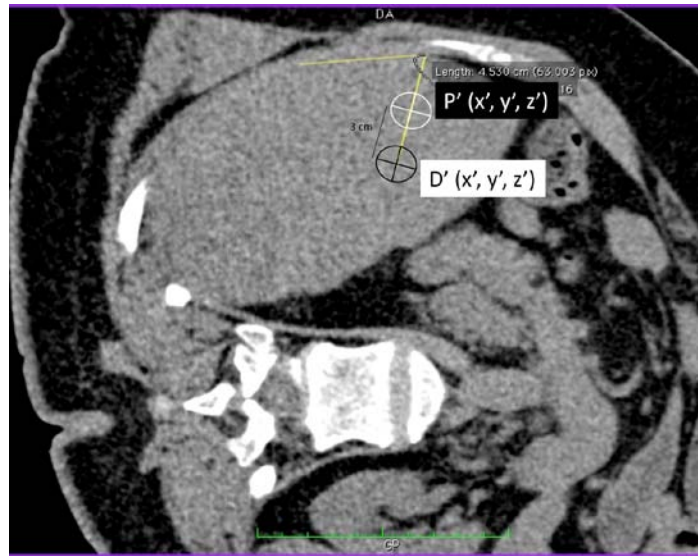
Reconstruction of the virtual CT plane with the initial CT volume to get virtual coordinates of the tip of the needle ($D'(x', y', z')$) and a point on the needle 3cm proximally from the tip ($P'(x', y', z')$). All of the organs seen on the picture have to present the same aspect as on the virtual CT plane (figure 1, left side). Once the good plane obtained, same angulation and distance of the needle in the liver as seen on real US image are reported on the plane and virtual coordinates calculated.
